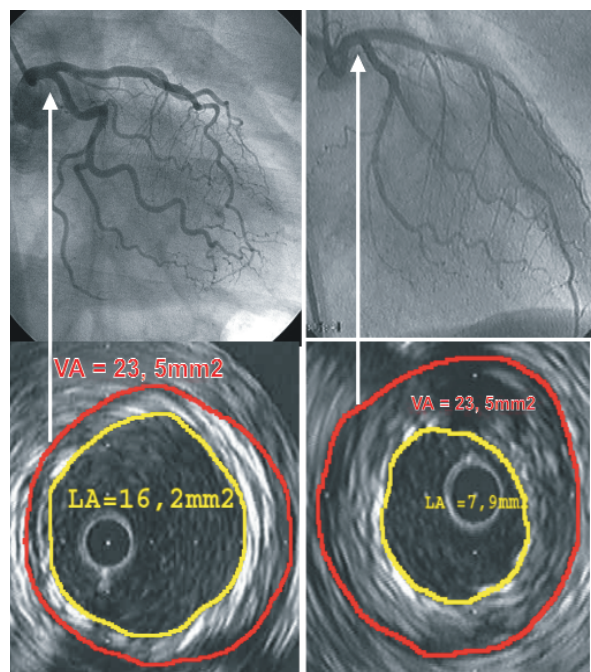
Coronary angiography of LMS – above, Intracoronary ultrasound of LMS- the same segment – below
